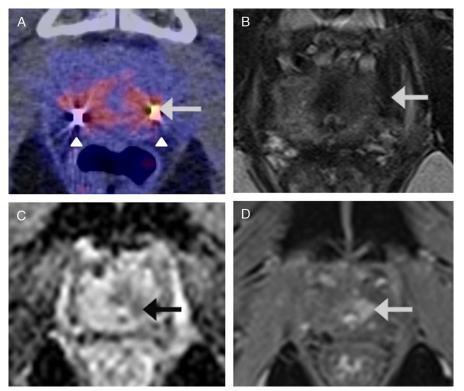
A 53-year-old patient with biochemical recurrence (prostate-specific antigen [PSA] 9.1 ng/mL) after external beam radiation therapy (EBRT). Axial ⁶⁸Ga-PSMA PET/CT (A) shows the gold markers placed for EBRT (arrowheads) and focally increased uptake (arrow). The latter was prospectively interpreted to be due to metal artifacts.¹ There were no signs of metastatic disease. Multiparametric MRI (mpMRI) performed 6 days later showed a local recurrence in the left peripheral zone on axial T2-weighted (B, arrow), apparent diffusion coefficient map (C, arrow), and contrast-enhanced (D, arrow) images. Targeted MRI transrectal ultrasound (TRUS) fusion biopsy confirmed recurrent disease (Gleason 4 + 3). In post-EBRT patients, recurrent disease may be confused for metal artifacts on ⁶⁸Ga-PSMA PET/CT (and vice versa). A helpful hint to avoid this pitfall and to suggest recurrent disease instead of a true metal artifact is the absence of "artifactual" uptake around other gold markers.
